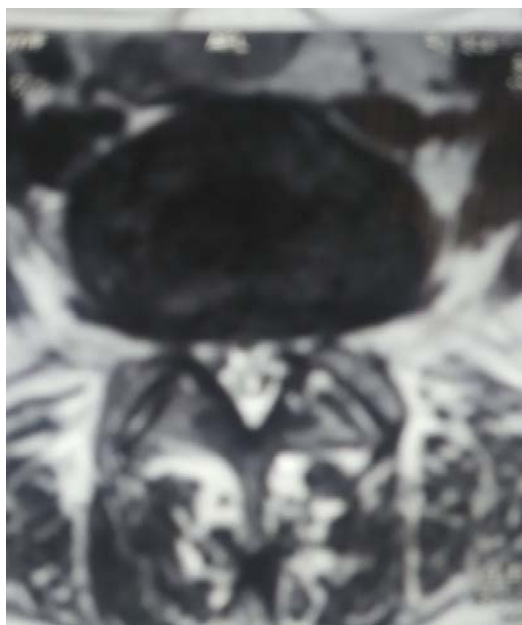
MRI lumbar spine axial section showing regression of previous left paracentral disc herniation at L5-S1 level
